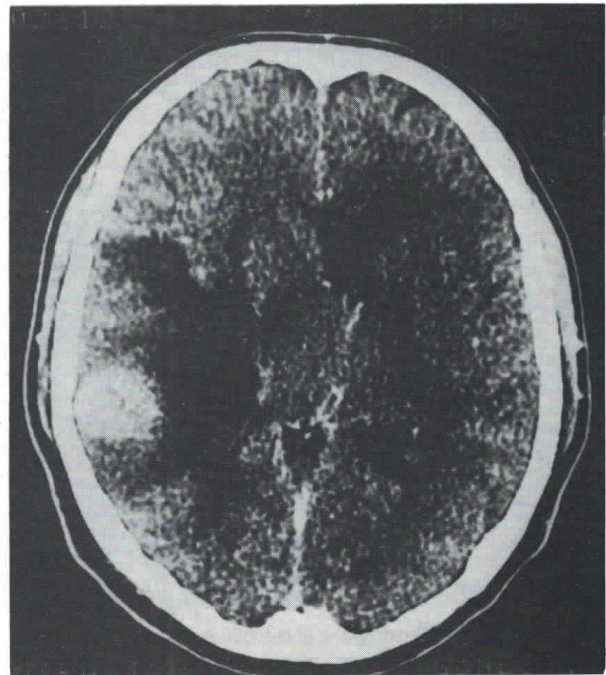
(Case 5) Postcontrast CT scan reveals a parietal tumor with a peritumoral cyst.
